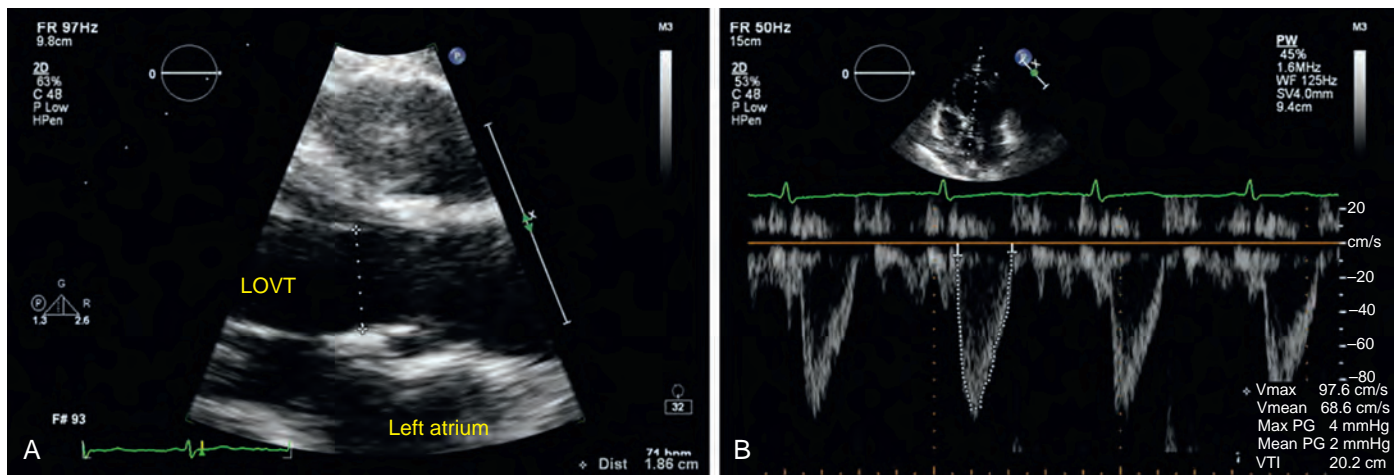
Echocardiographic estimation of cardiac output at the left ventricular outflow tract (LVOT). A, LVOT diameter is measured from the parasternal long-axis view in midsystole. B, Measurement of the LVOT velocity-time integral (VTI) using pulsed-wave Doppler ultrasonography in apical five-chamber view. See text for details.
